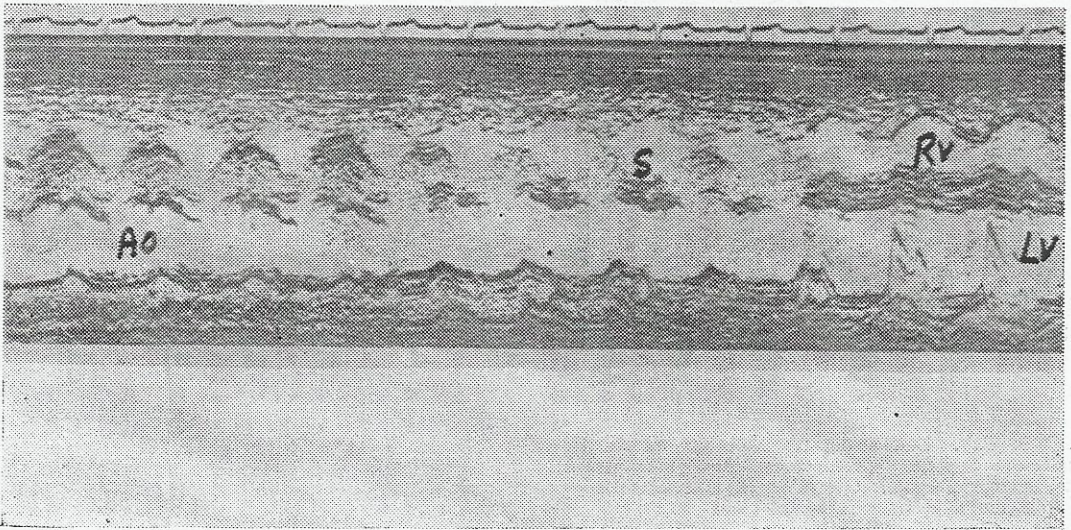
M-mode echocardiogram in a patient with Tetralogy of Fallot. Note overriding of AO above the ventricular septum(s). R.V. is markedly hypertrophied.
